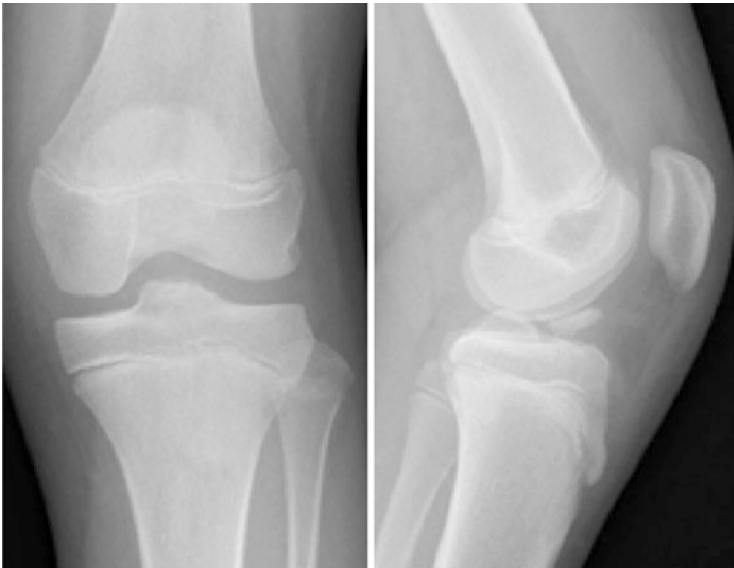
X-rays of a 12-year-old girl. Anteroposterior view (*left*). Lateral view (*right*)
